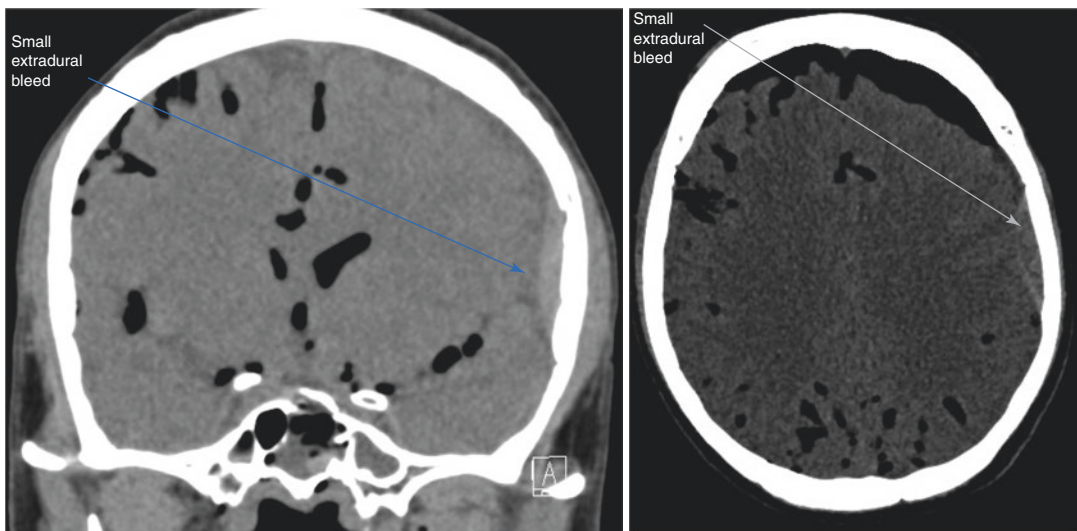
CT scan of left sided extradural haematoma in sagittal (bottom) and coronal (top) slices
